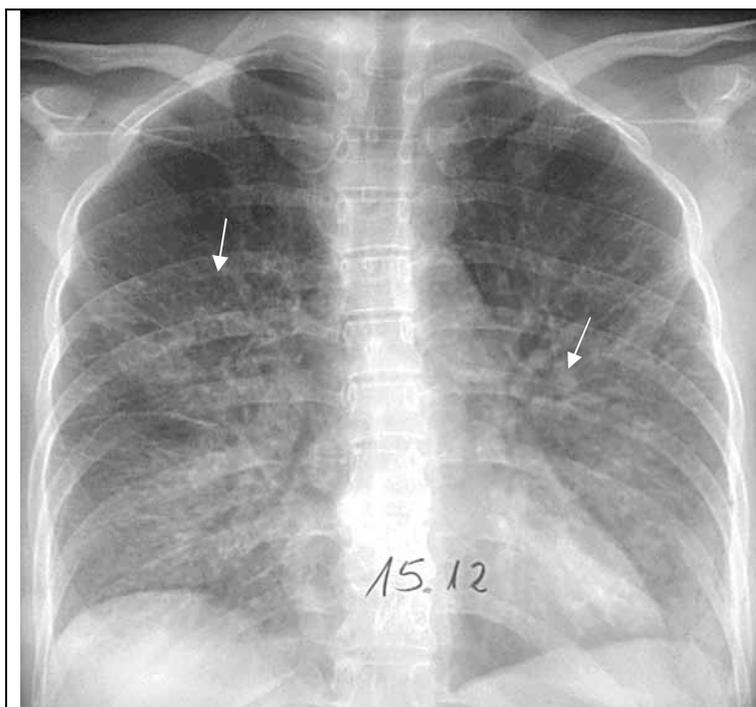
The survey radiograph of a thorax in direct projection. Structure of roots of both lungs is indistinct. Lung pattern of both lungs is intensified and deformed in the middle and inferior departments with developing of cellular structures (arrow). In the root region of left lung focal shadows of small intensity (arrow with rombus). Viral pneumonia.
